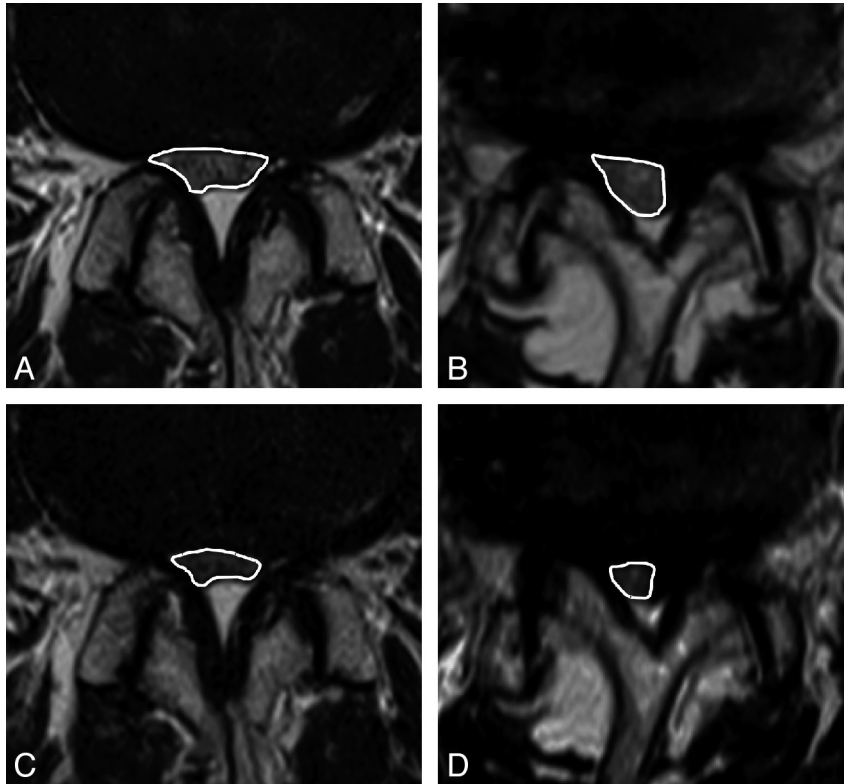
The measurement of DCSA on conventional MR imaging and axial loaded MR imaging in representative patients with SpS (A and C) and DS (B and D). The white lines indicate the outlines of the DCSA. In the first patient with SpS, the DCSA changed from 67 (A) to 41 mm² (C) due to the axial loading. In the second patient with DS, the DCSA changed from 52 (B) to 25 mm² (D).
